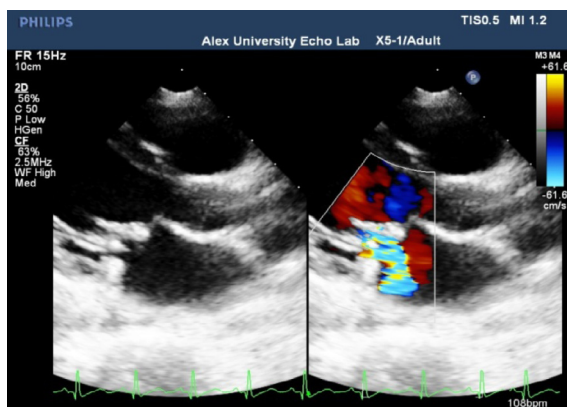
Figure G 2D TTE long axis view with color Doppler showing a residual mild central mitral valve regurgitation.
